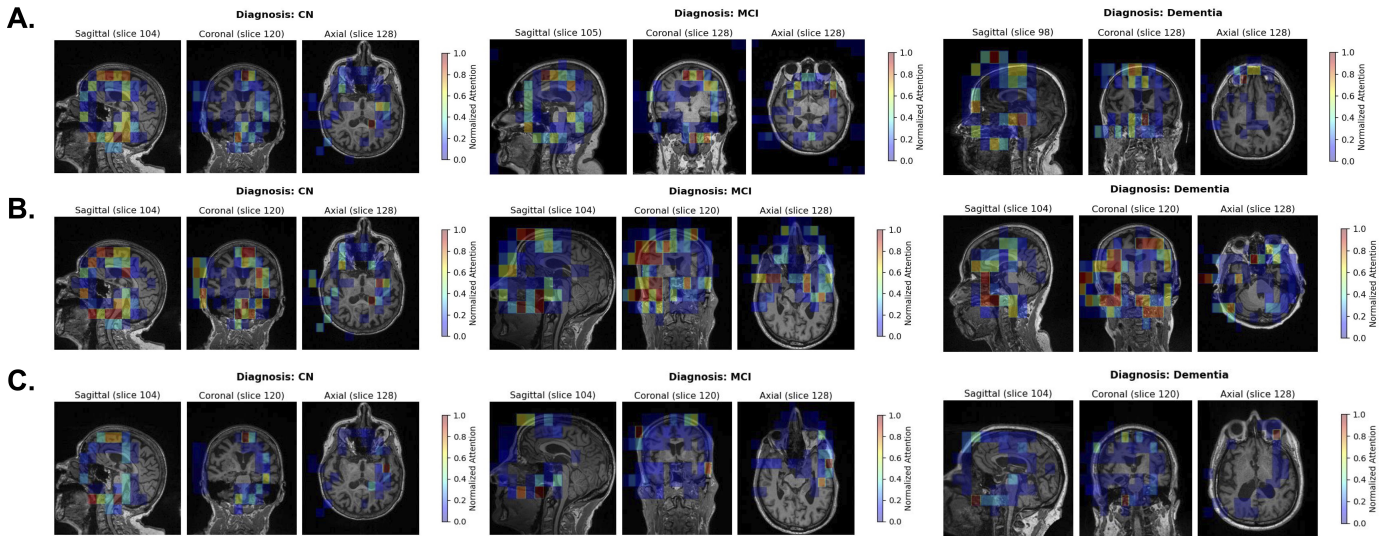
Generated attention maps overlaid on MRI slices using A) Baseline attention mechanism (gating) B) Non-linear attention (no gating) and C) Temperature-scaled gated attention.
